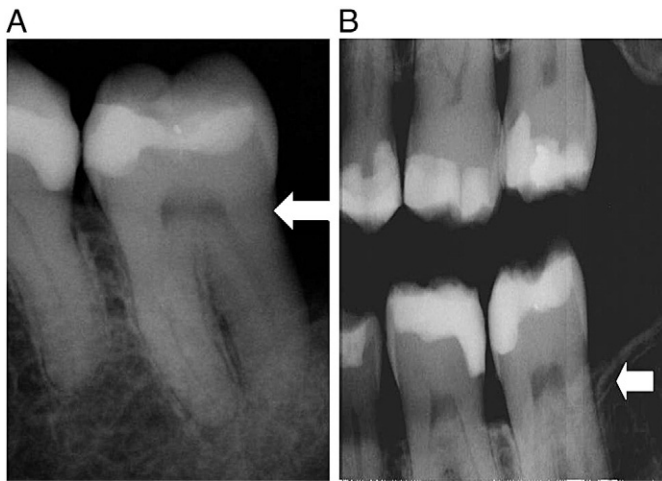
A) Arrow shows radiograph of bone level two years prior to reported tissue loss; B) Arrow shows bone level at the time of presentation, indicating significant bone loss.
